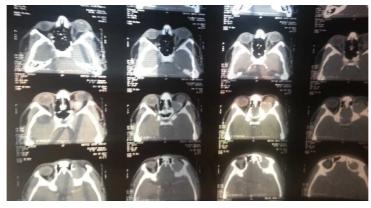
CT of the orbit showing the brown tumor
